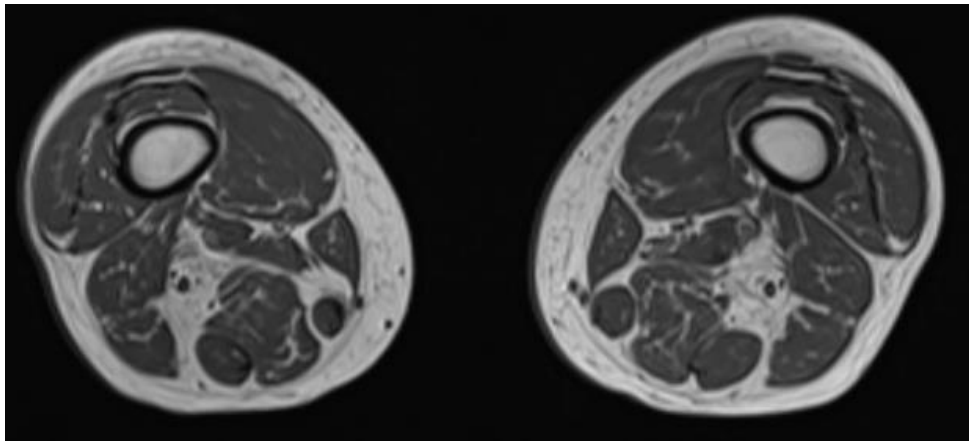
Magnetic Resonance Imaging (MRI) of lower extremities from the patient.
